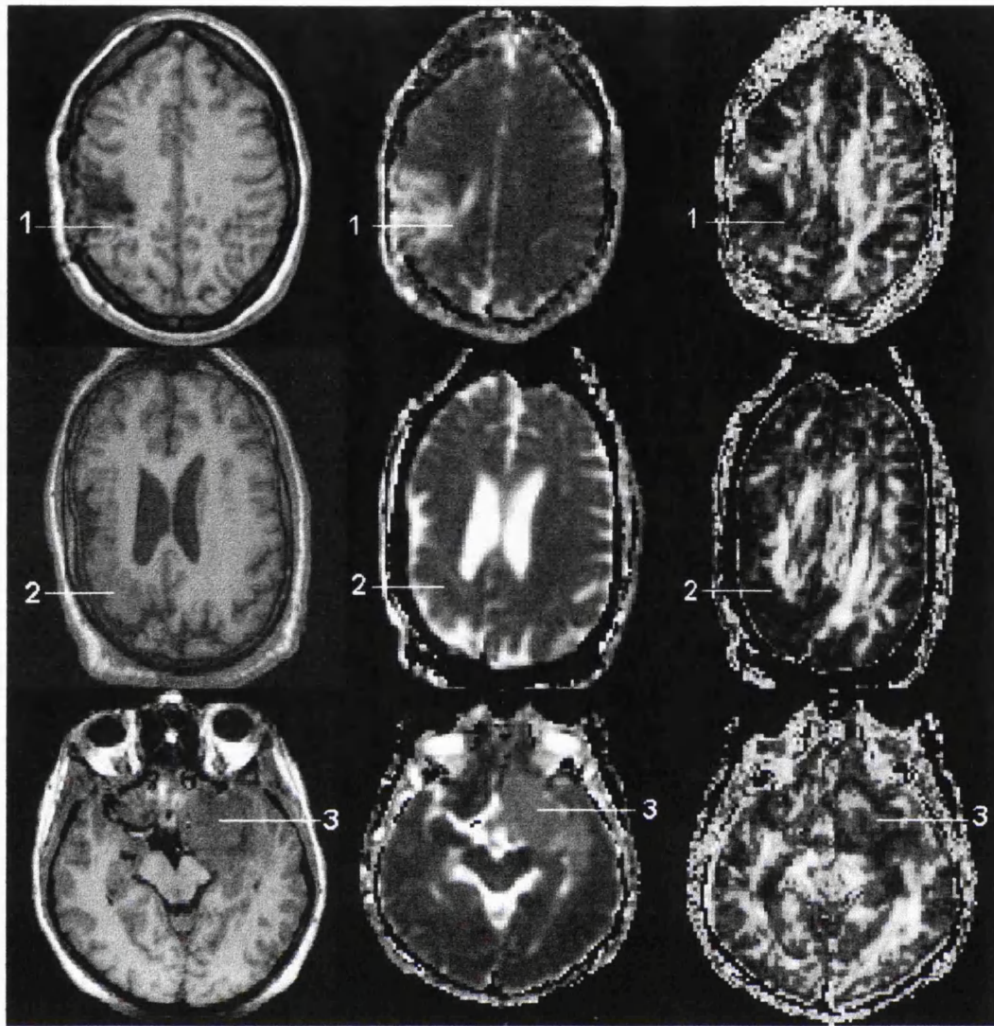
Structural abnormalities on DTI. T1-weighted images (left), maps of mean diffusivity (middle) and fractional anisotropy (right) are shown. Top row: A patient with traumatic brain damage affecting the right parietal and frontal lobe (1). Middle row: A patient with polymicrogyria affecting the right hemisphere (2). Bottom row: A patient with a left temporal meningioma (3). The fractional anisotropy is reduced in all structural abnormalities. However, mean diffusivity is only mildly increased in the patient with polymicrogyria.
